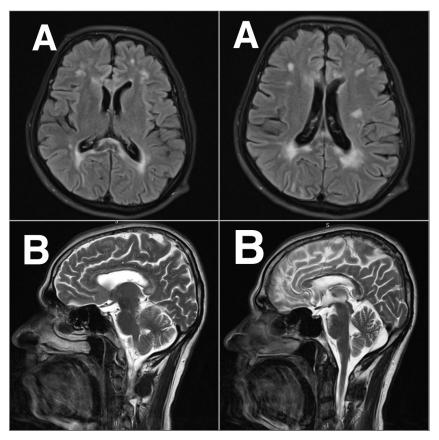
MRI images (A) FLAIR Axial and (B) FLAIR sagittal images showing atrophied corpus callosum and increased FLAIR signals in genu, body and splenium. Diffuse high FLAIR signals are seen in the periventricular white matters bilaterally sparing subcortical U fibers.
